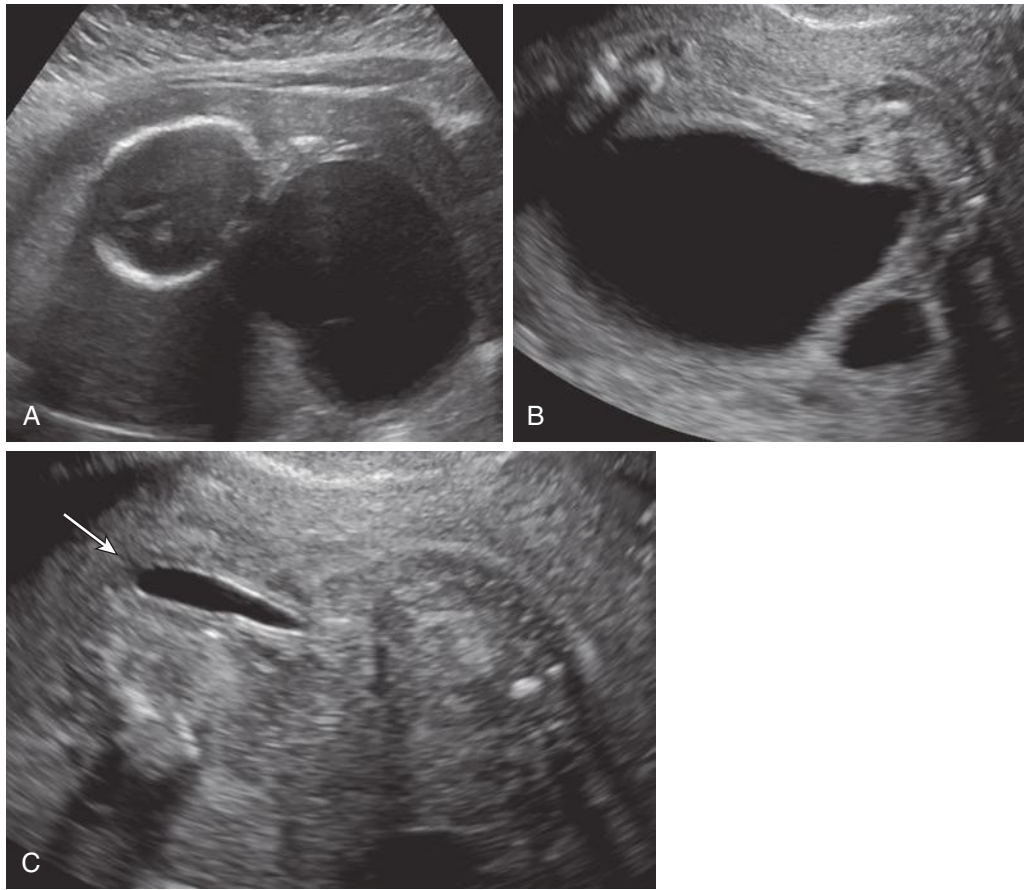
Congenital megalourethra. A, Breech fetus with severe oligohydramnios and markedly distended urinary bladder. These sonographic findings are similar to those seen with bladder outlet obstruction due to posterior urethral valves. B, Coronal view of dilated urinary bladder with dilation of the prostatic urethra. C, Targeted transvaginal sonographic images reveal dilated, elongated penile urethra (*arrow*).
